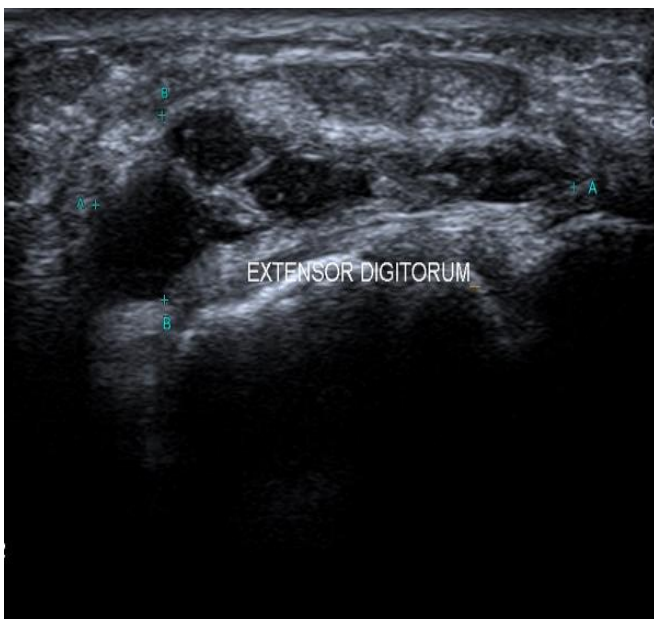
and 10): A 29 years old female patient complaining from dorsal wrist pain and swelling. Figure 9 shows Ultrasound images show (A) lobulated ganglion cyst related to extensor digitorum compartment with stations and echoes. Figure 10 shows MRI images show same ultrasonographic findings.
